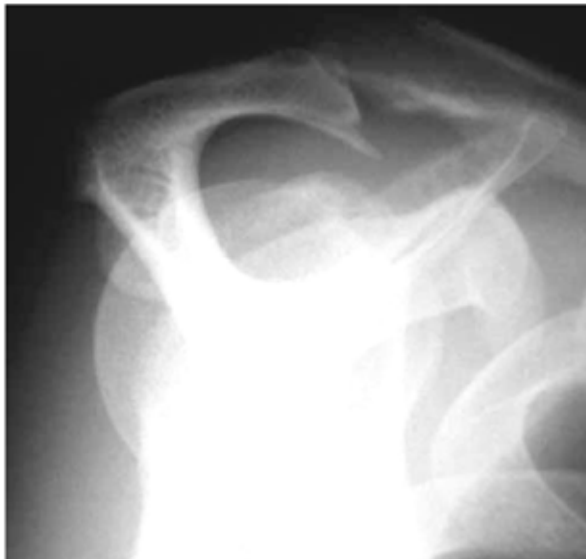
Plain radiograph of a type III acromion with a prominent acromial enthesophyte⁸
